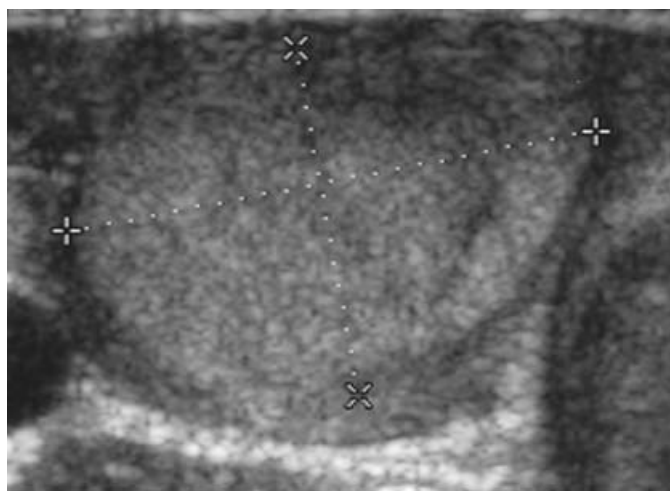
A 38-year-old woman with a palpable thyroid nodule. Transverse sonogram of the right lobe of the thyroid shows a well-defined hyperechoic nodule with homogenous texture, without calcification or cystic formation.
